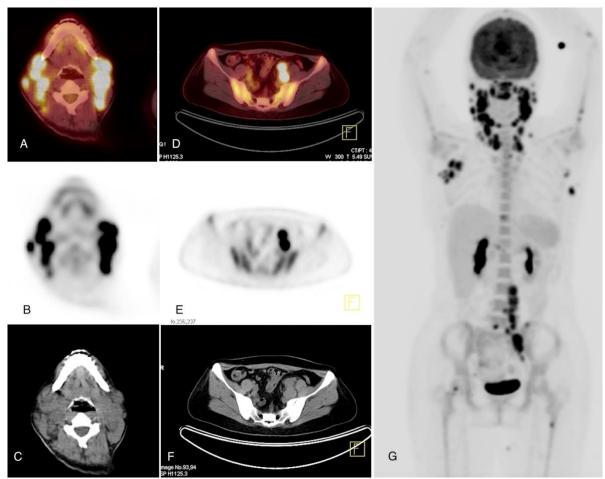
PET/CT fusion (A), PET (B) and CT (C) images demonstrated hypermetabolic lymphadenopathies in the bilateral periparotid and bilateral cervical zone II. PET/CT fusion (D), PET (E) and CT (F) images revealed highly active lymph nodes in the left external and internal iliac regions. MIP (G) image revealed extensive lymphadenopathies involving multiple anatomic sites
